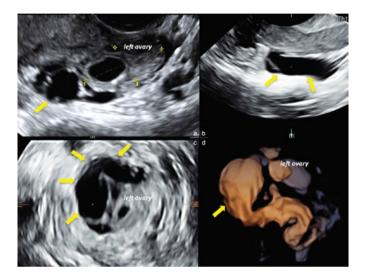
3D ultrasound with multiplanar view of a hydrosalpinx (yellow arrows) adhered to the left ovary. Presence of a dilated uterine tube with liquid content, thin walls (*c*), incomplete septa (b), and small hyperechoic mural papulations in the transverse section (a). The 3D volume reconstruction clearly shows the typical flask-shaped tubular structure ³.
